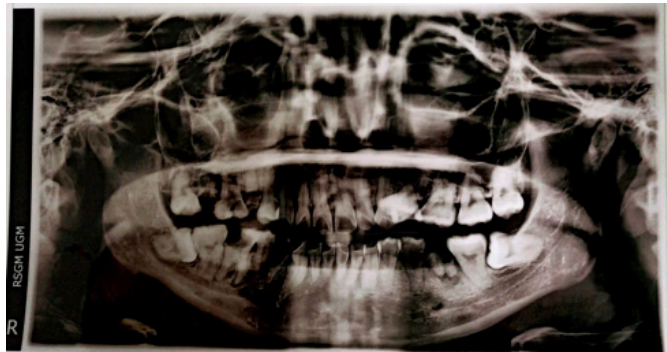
Panoramic radiograph taken on first visit, no bone loss around the left lateral incisor of the maxilla.
